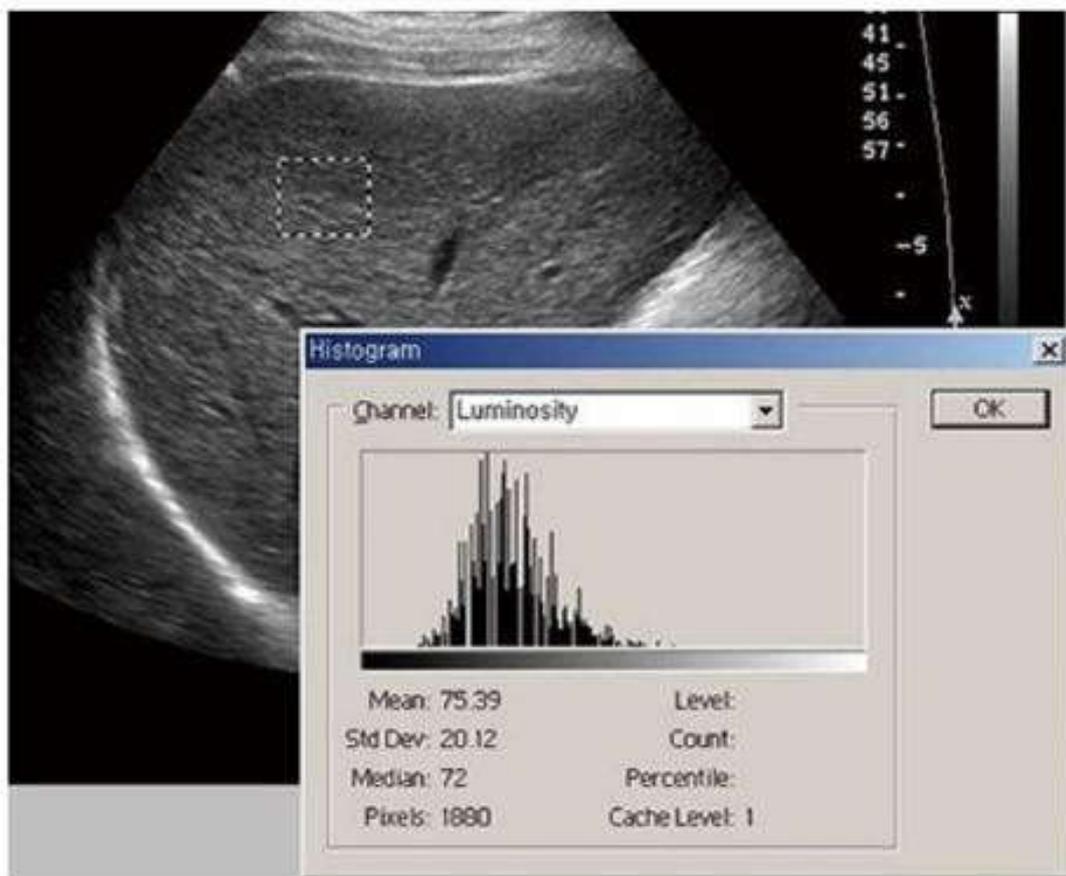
The region of interest of texture analysis is positioned in the right lobe of the liver, with an intercostals scan performed with gray scale ultrasonography. Chronic liver disease patient shows heterogeneous parenchymal echogenicity with high standard deviation value (Area: 1880 pixels, Mean: 75.39, SD: 20.12)
